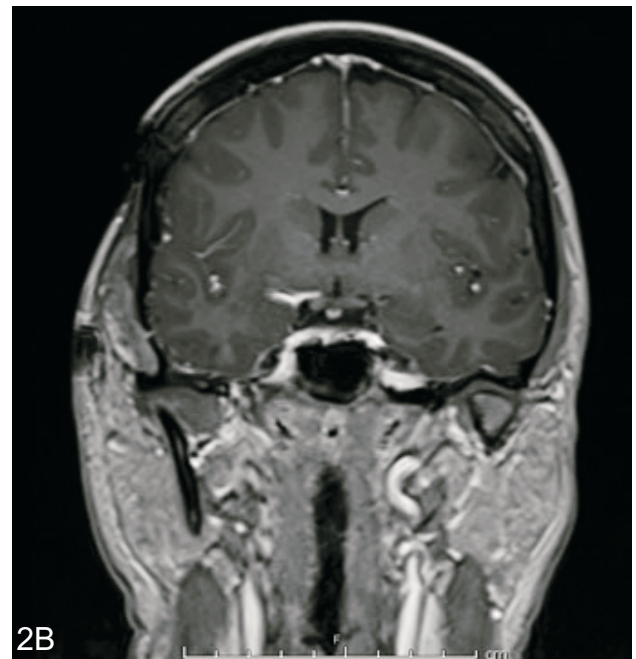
Postoperative MR imaging (the next day after surgery) of the patient with suprasellar meningioma A) The contrast enhanced sagittal MR image B) The contrast enhanced coronal MR image C) The contrast enhanced axial MR image show the total removal of the tumor. The pituitary gland appears as normal.
